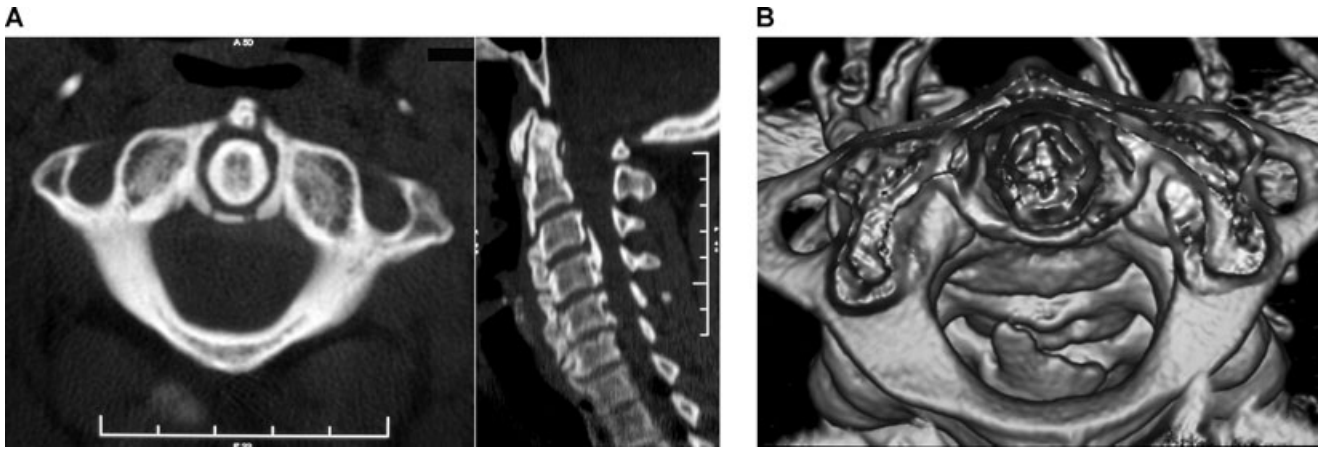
CT of the cervical spine of a 58-year-old woman complaining of dizziness, limited rotation of the head, and paresthesia of the upper limbs. Axial (A, left) and reformatted sagittal (A, right) images show a thick calcification of the transverse ligament associated with voluminous, flowing osteophytes and calcification/ossification of the anterior and posterior longitudinal ligaments. A volume-rendered display (B) shows in an elegant way the calcified transverse ligament and a huge calcification of the longitudinal posterior ligament protruding into the spinal canal at C3-C4 level.
